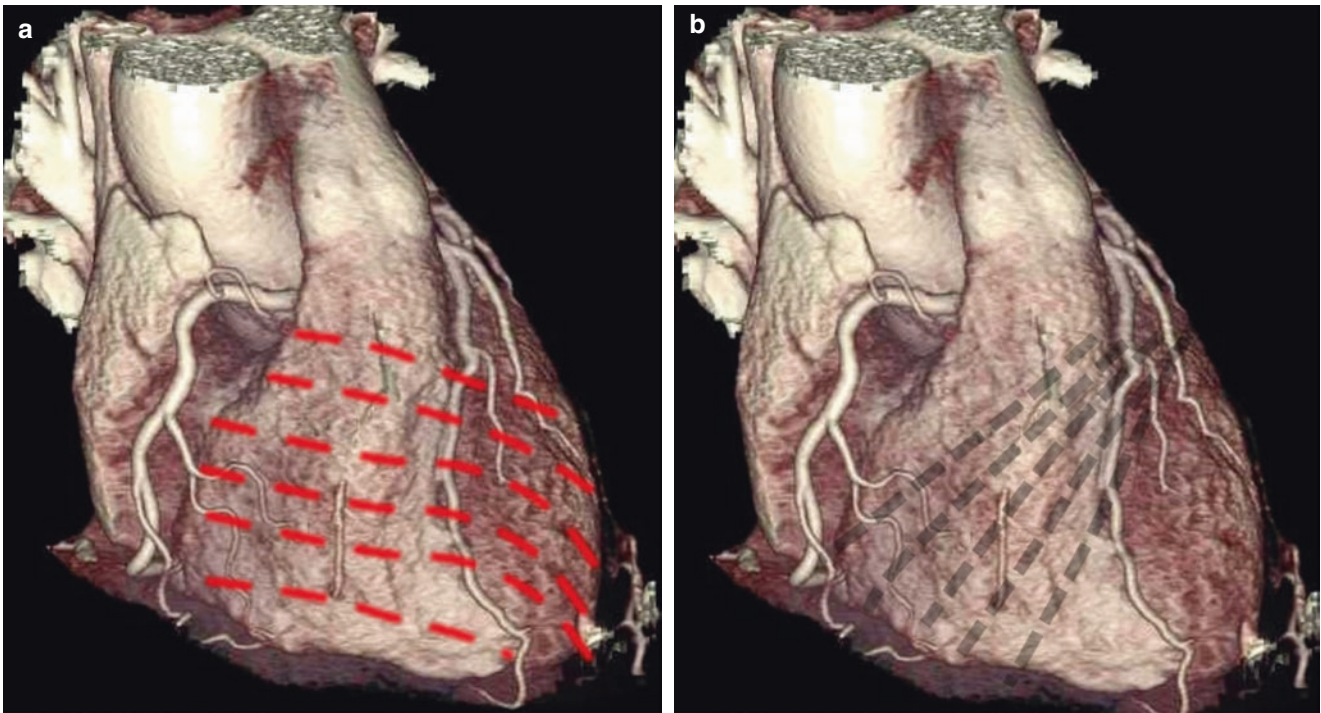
(a) CT volume-rendering images showing the RV fibers of subepicardial layer (*red thick dotted line*) and the RV fibers of subendocardial layer (*b*, black dotted line) (see text)
